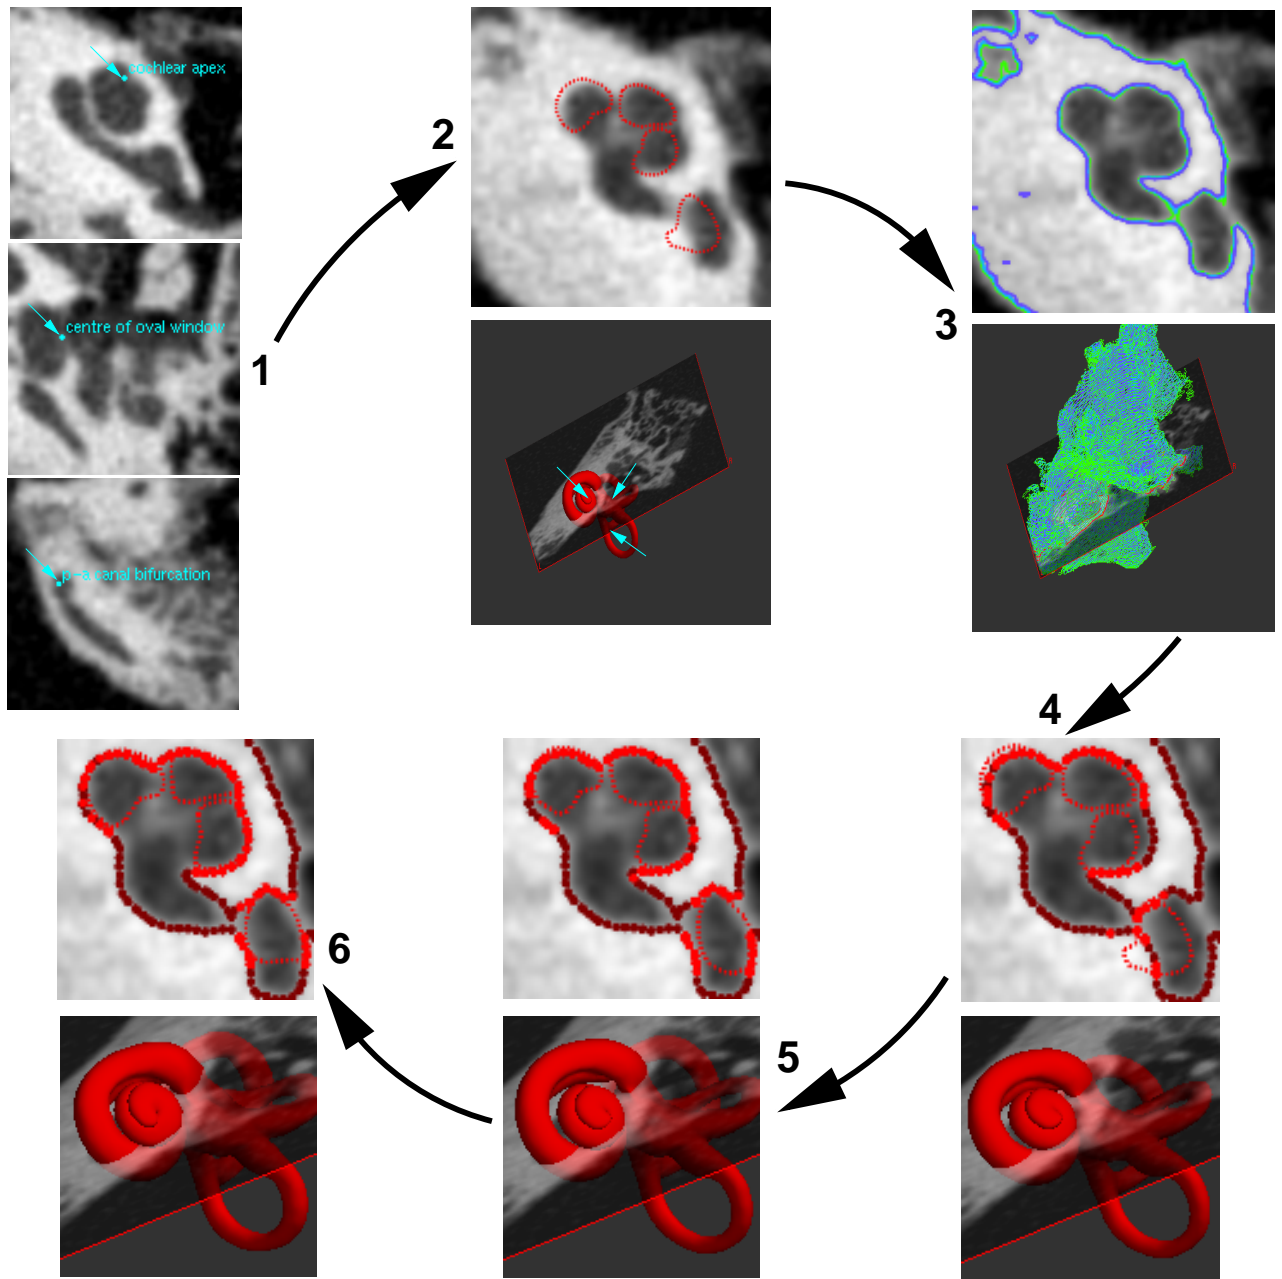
Fitting a model to CT data. (1) The operator scrolls through the axial CT images and places landmarks at the cochlear apex, the centre of the oval window and the posterior-anterior canal bifurcation (at the tip of the crus commune). (2) These landmarks are matched with corresponding, pre-defined landmarks on the model. An initial, approximate alignment is provided by the similarity transformation (rigid body plus uniform scaling) that minimizes the sum of the squared distances between the three pairs of landmarks. (3) The operator selects a suitable segmentation threshold: this subfigure shows contours thresholded at grayscale 160 (green), 170 (cyan) and 180 (purple). (4) The contour vertices at the selected threshold (170 in this example) provide the point cloud to which the model is fitted. Points closest to a model vertex are displayed in bright red, other points in dark red. (5) Iterative closest point (ICP) registration of the model to the point cloud, with a similarity transformation. (6) Finally, the fit is refined using ICP registration with a nonrigid transformation, either a statistical shape model or a locally affine deformation.
